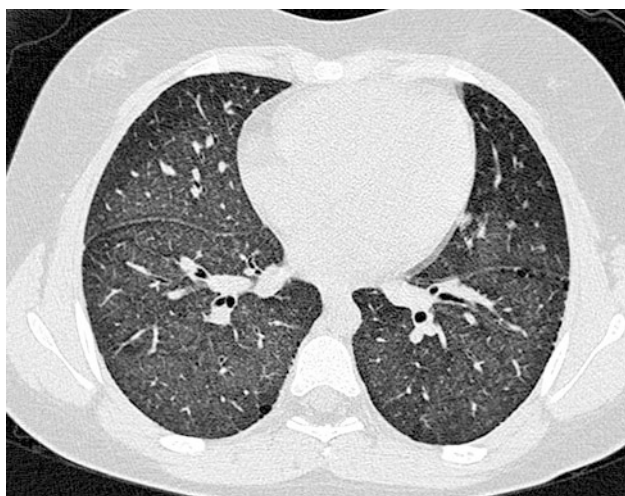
A 3-year-old girl with hemosiderosis. HRCT shows ground-glass attenuation due to pulmonary hemorrhage
